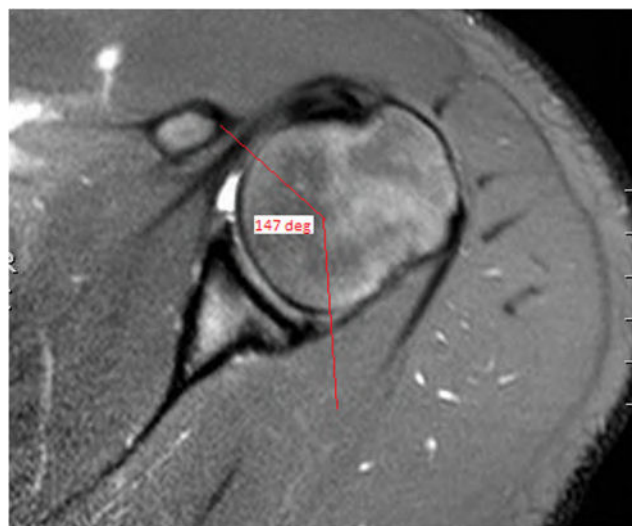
An axial cut on a shoulder MRI shows the measurement of the intact anterior articular surface (IAAA)
